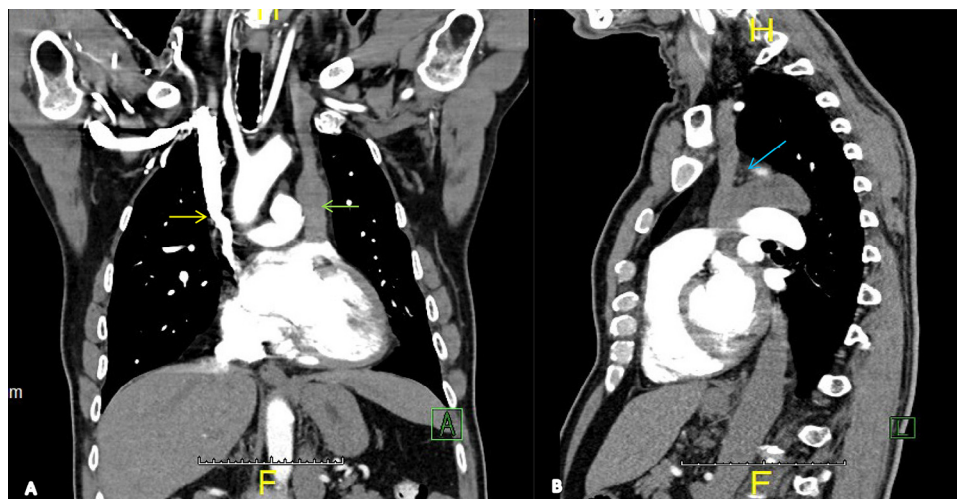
(A) Coronal computed tomography images demonstrate right superior vena cava draining to the right atrium (yellow arrow) and the left inferior vena cava draining via the coronary sinus to the right atrium (green arrow). (B) Sagittal computed tomography image demonstrates reverse curve confluence of the left superior vena cava and the left hemiazygos vein (blue arrow).
